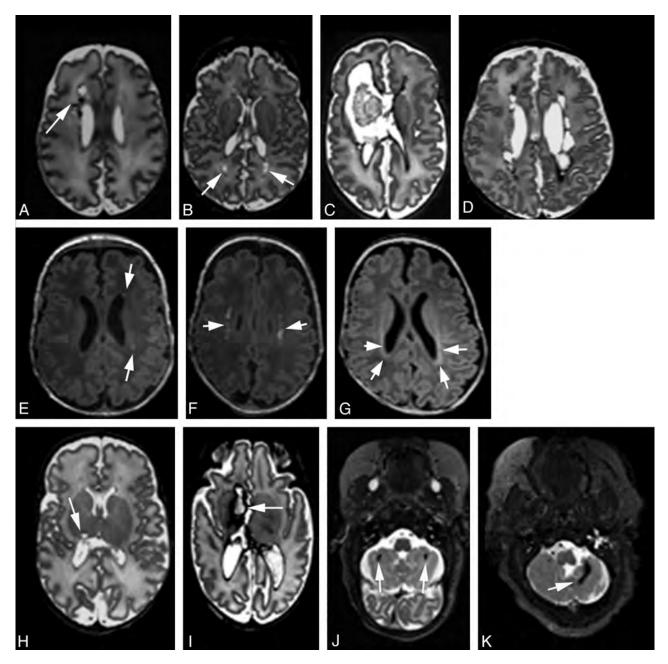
Representative MR images of regional injury. Axial TI- or T2-weighted MR images demonstrating classification of cystic WM lesions (A-D), focal WM signal abnormalities (E-G), deep GM lesions (H and I), and cerebellar lesions (I and K). Cystic WM lesions are defined by their extent: focal unilateral (*arrow*, A), focal bilateral (*arrows*, B), extensive unilateral (C), and extensive bilateral (D). Focal WM signal abnormalities are classified as focal punctate (*arrows*, E), extensive punctate (*arrows*, F), or linear lesions corresponding to gliosis (*arrows*, G). Deep GM and cerebellar injuries are classified into 4 grades by their extent. Representative images of focal unilateral (*arrow*, H) or extensive unilateral (*arrow*, I) deep GM lesions, and images of focal bilateral (*arrows*, J) or focal extensive (*arrow*, K) cerebellar lesions are shown.
